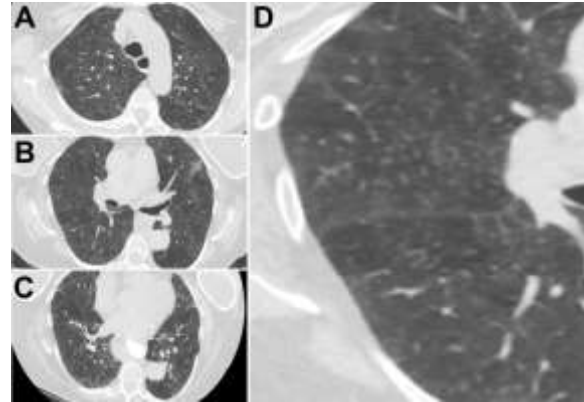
A-C: Representative images from outside thoracic CT scan in lung windows. D: enlarged view of right lung from Panel B. ([Click here to open Figure 2 in a new window](#))
